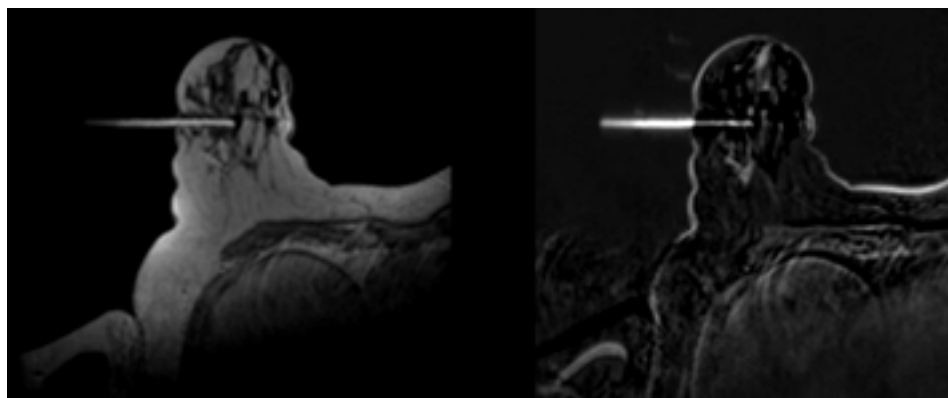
MRI-guided biopsy. T1-weighted images after contrast administration with a visible biopsy needle
